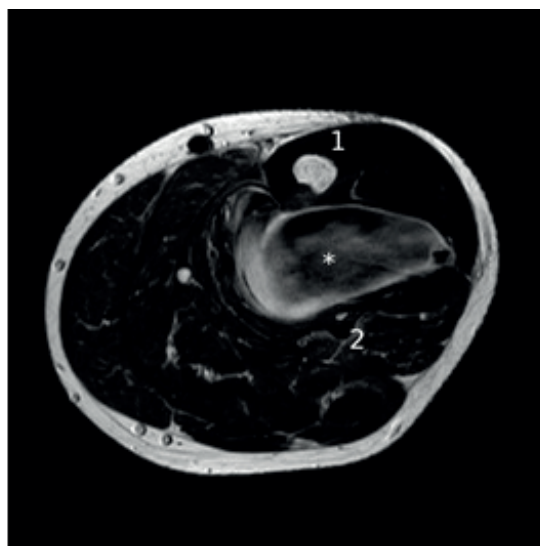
MRI (axial, T2) of the lower leg, 15 cm distal to the knee joint space (image courtesy of Radiologie 360°): (1) tibia, (2) fibula, (*) «tumor».
